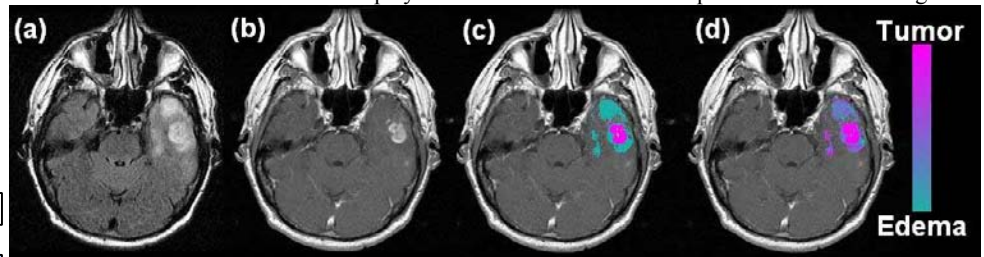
Example untreated *de novo* GBM case showing (a) FLAIR, (b) post-contrast T₁, (c) peritumoral (aqua) and tumor (magenta) areas defined by morphological images, and (d) final classification showing mixture of edema and edema with tumor in the peritumoral areas.
